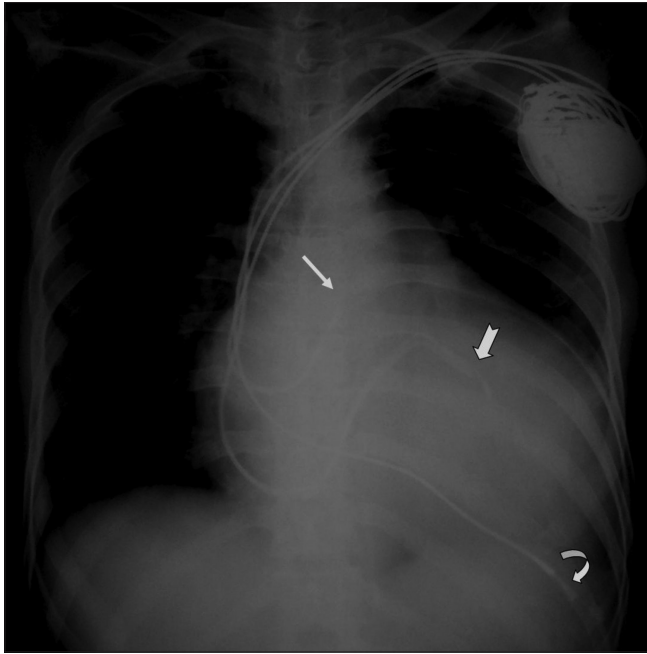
Frontal chest radiograph shows optimal position of a biventricular pacemaker. Besides the electrodes in the right atrium (straight arrow) and right ventricle (curved arrow), the third electrode is placed in the coronary sinus (notched arrow)
